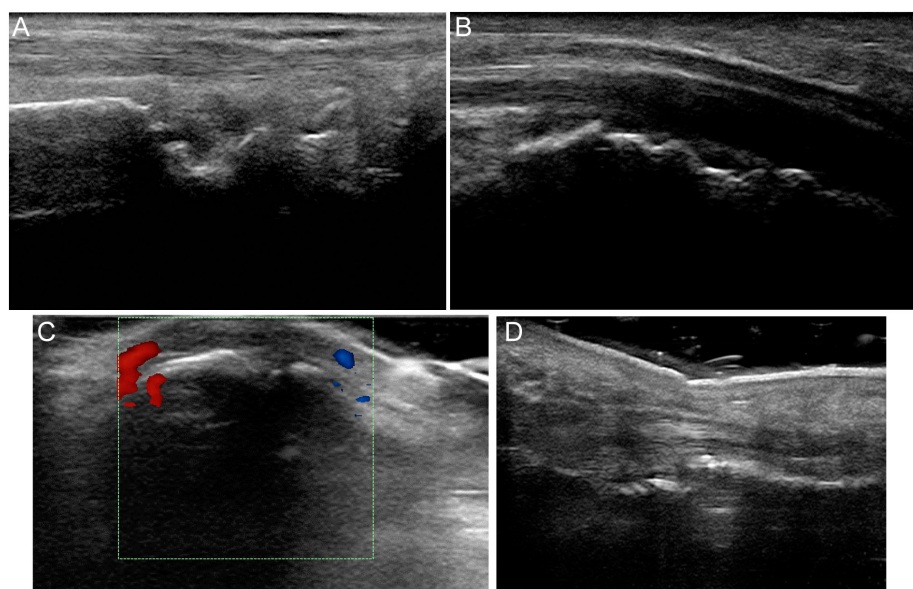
Arthritis revealed by ultrasonography. (A): Bone erosion of the left wrist joint shown by dorsal longitudinal scan. (B): Bone erosion of the left wrist joint shown by palmar longitudinal scan. (C): Synovitis of the left PIP4 joint shown by dorsal longitudinal scan. (D): Tendon contracture and joint misalignment of the left PIP4 joint shown by palmar longitudinal scan.
